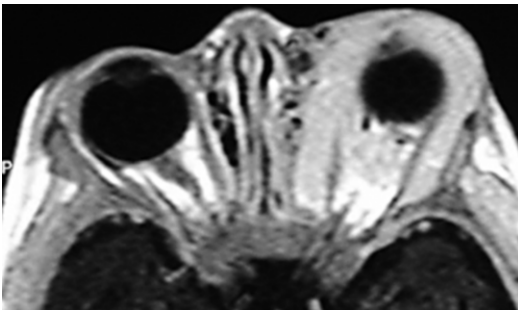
MR image of a capillary hemangioma with extra- and intraconal location in the left orbit
